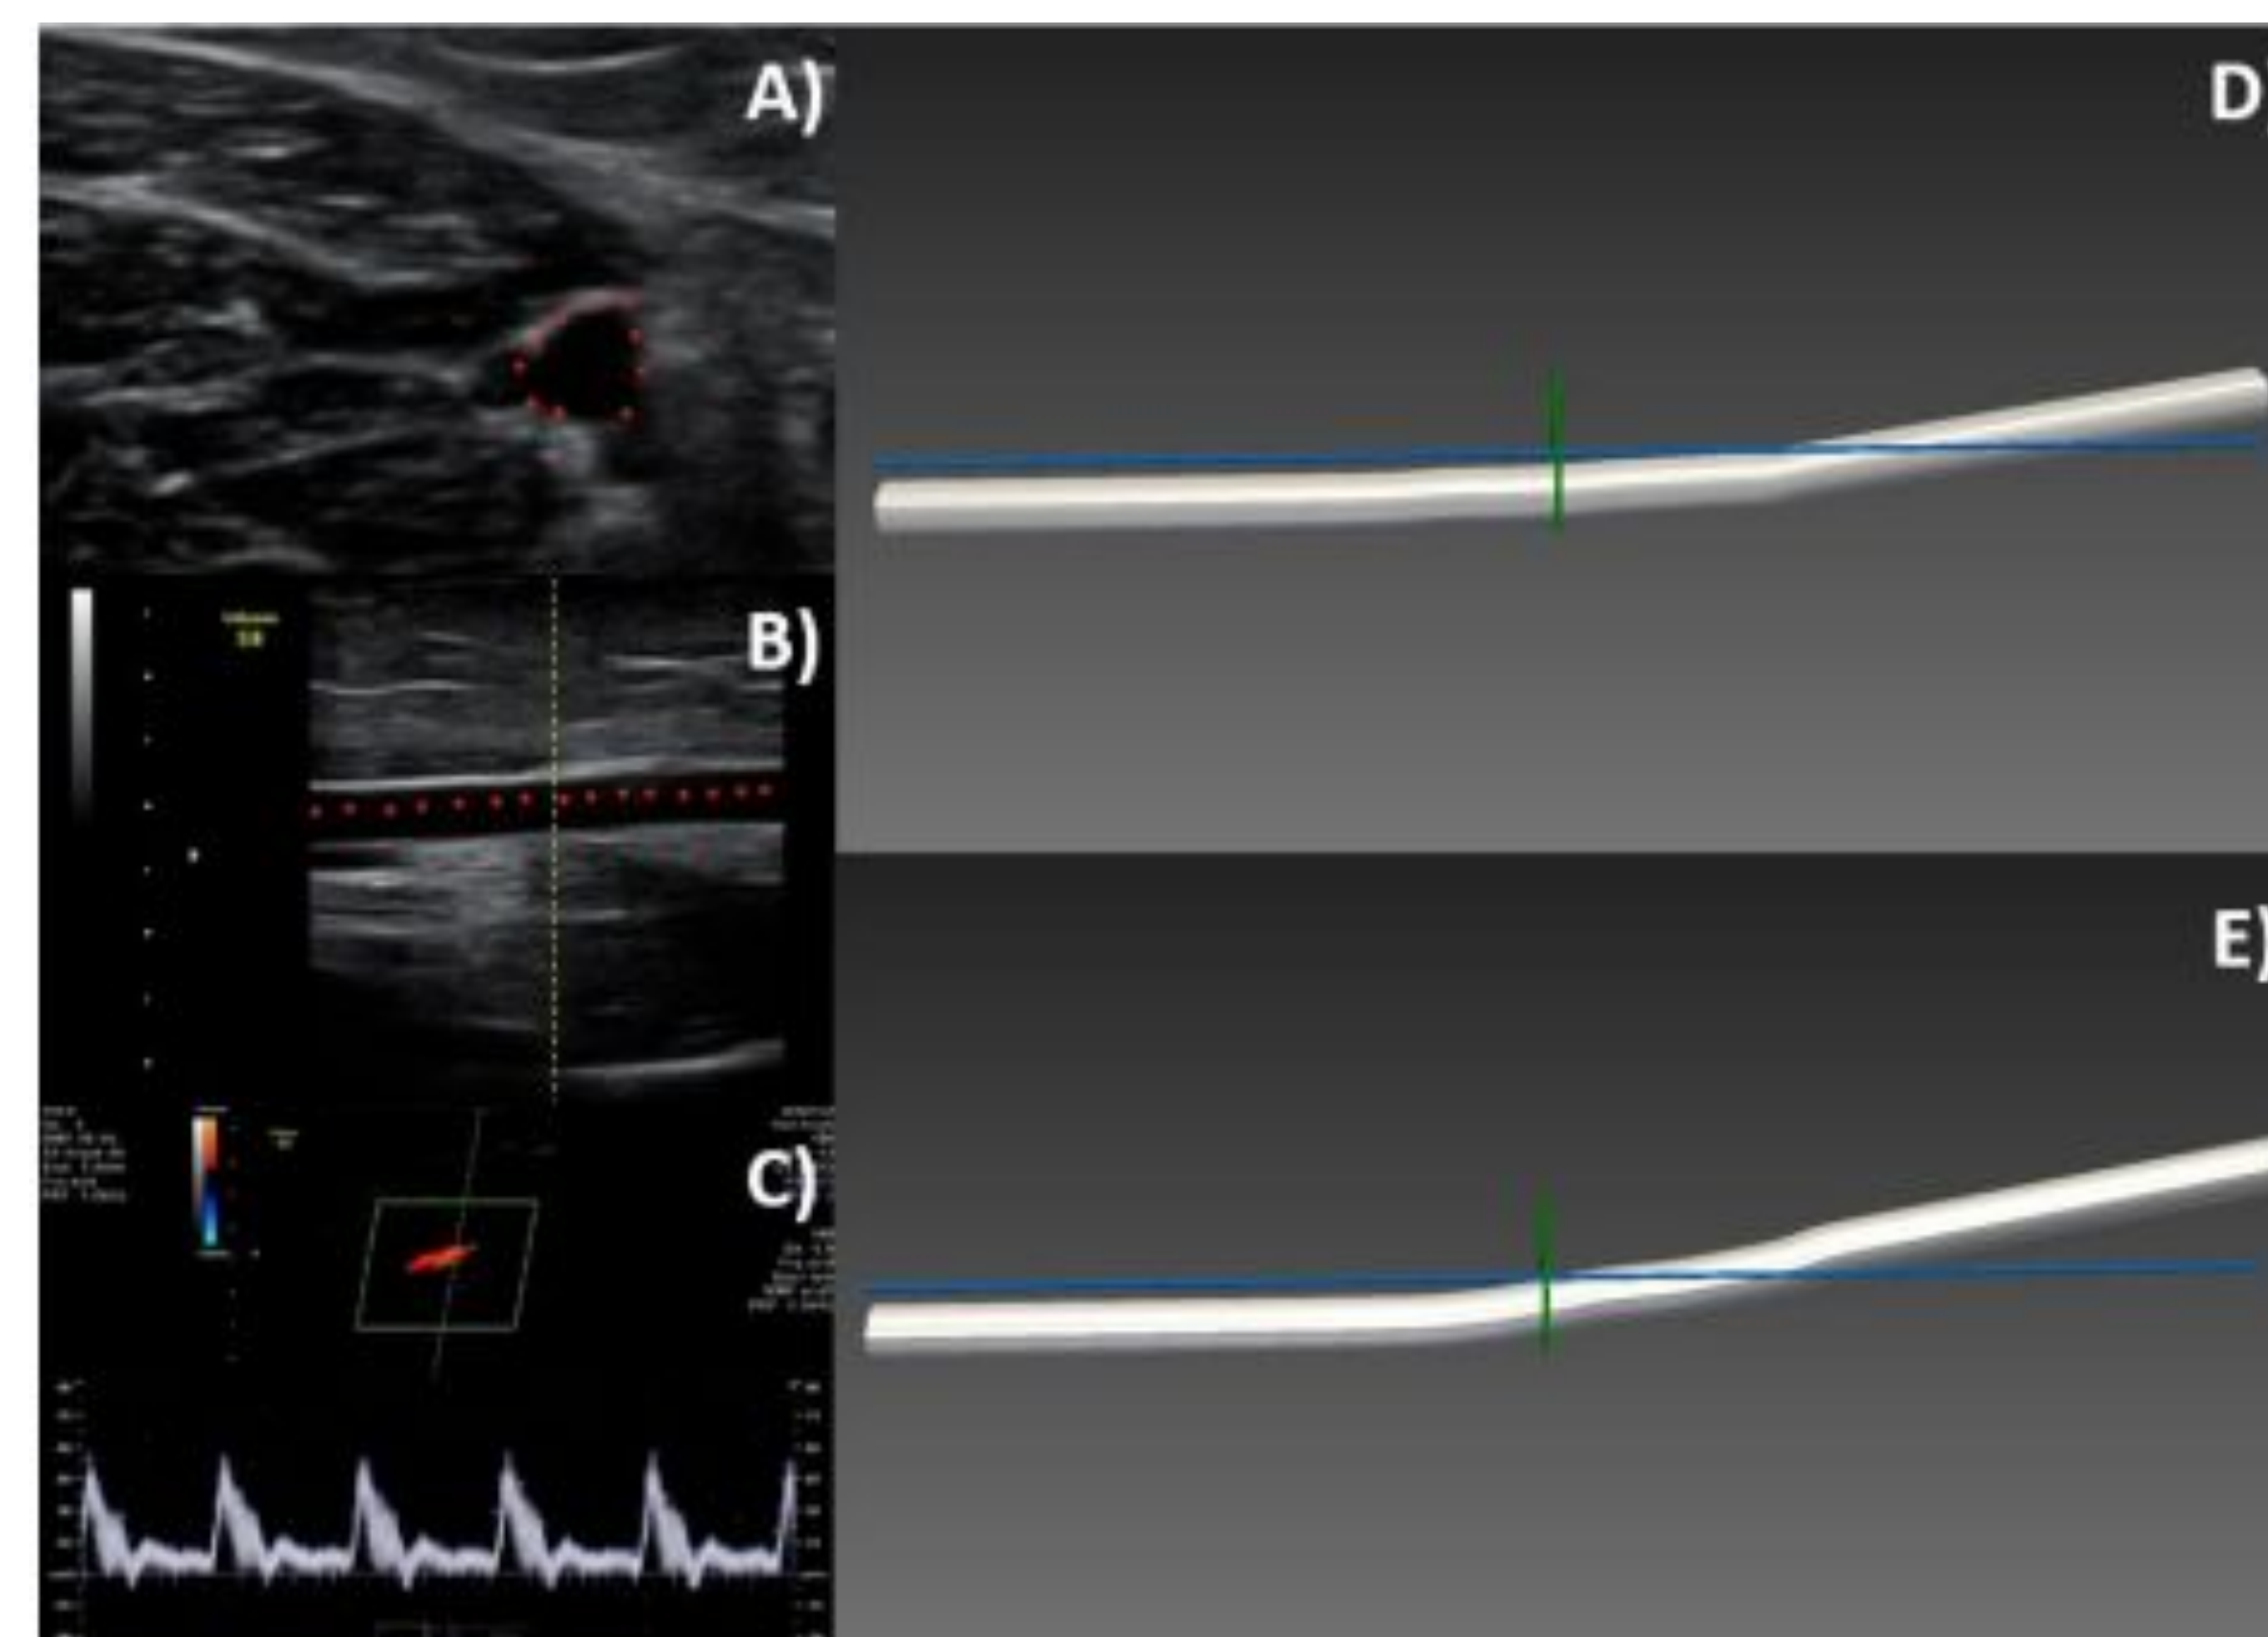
BA WSS evaluation pipeline. A) BA contour, B) BA length, C) velocity profile from doppler, D) pre and E) post-occlusion BA models.
